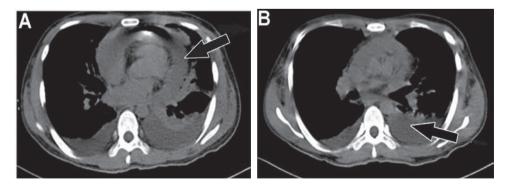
A chest CT showing a large amount of: A) pericardial effusion; and B) bilateral pleural effusion.
